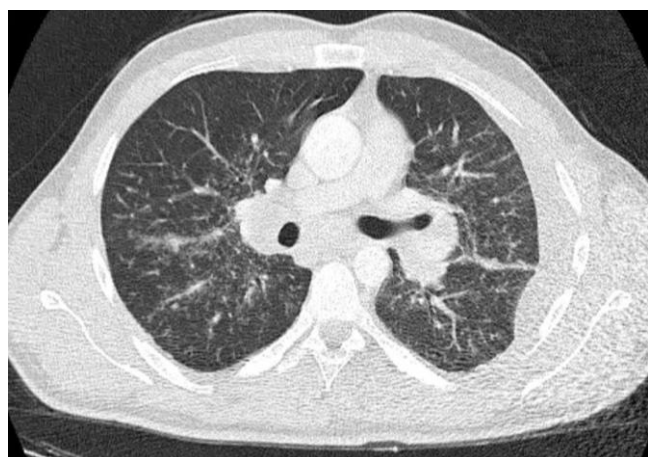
Thoracic CT findings.
